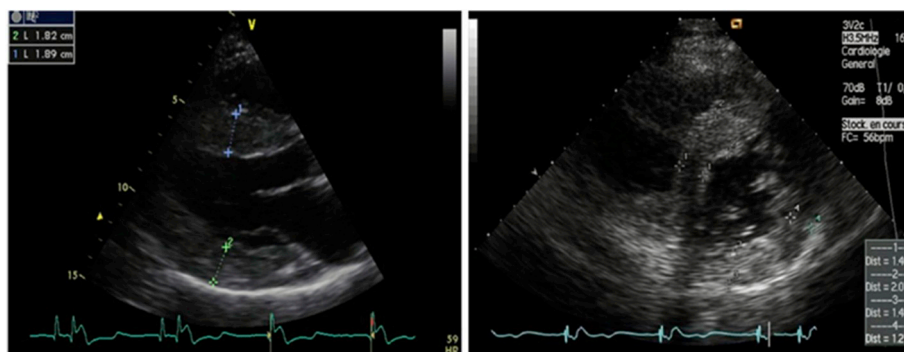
A – Severe left ventricular hypertrophy on transthoracic echocardiogram
